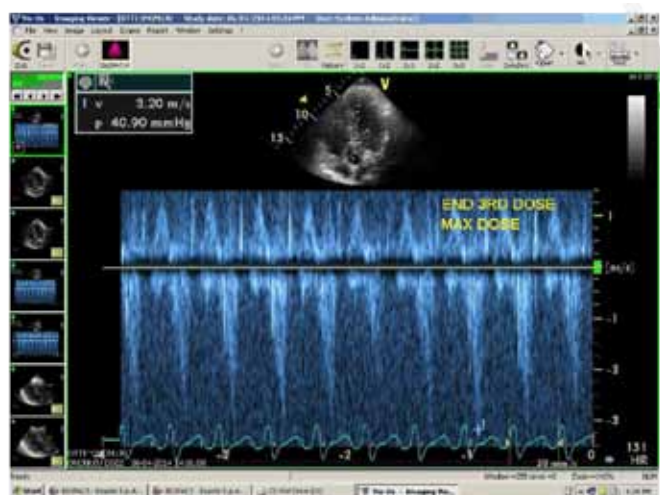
Stress echocardiogram showing a dynamic left ventricular outflow tract obstruction with a gradient of 40.9 mmHg.
